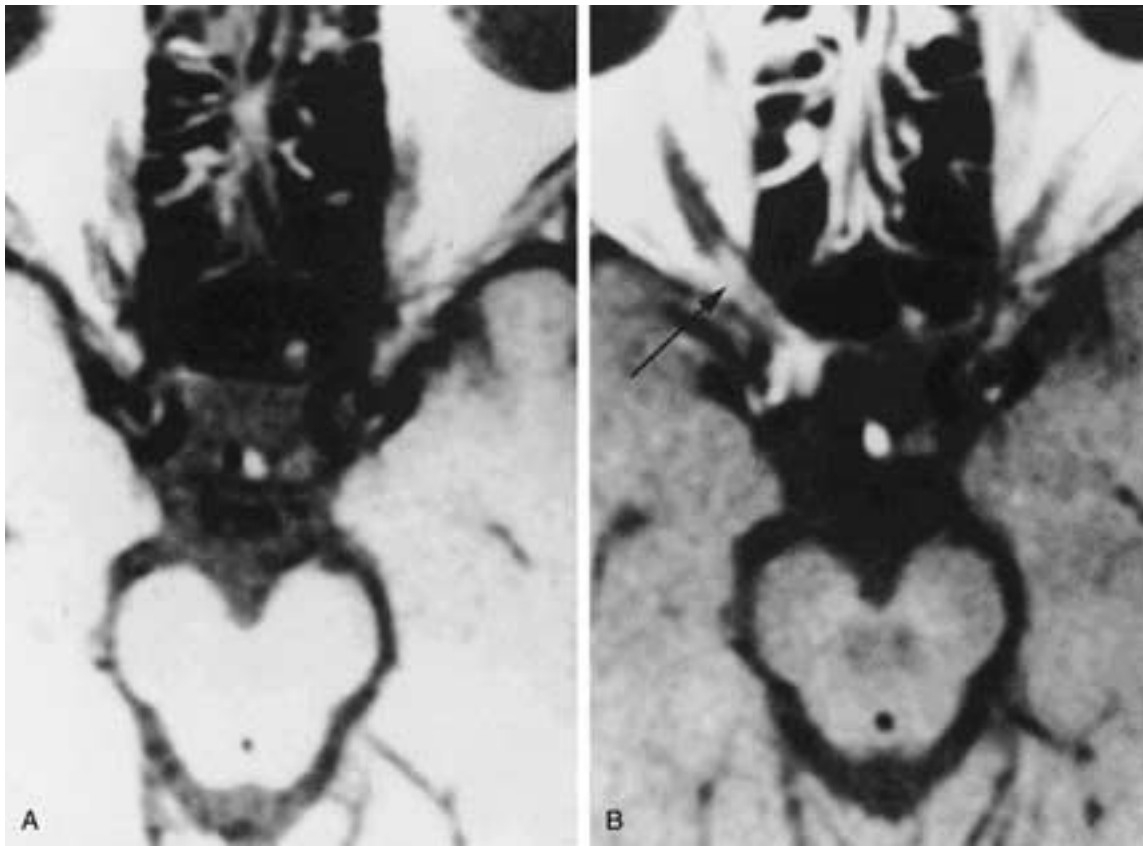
Perioptic meningioma. A, Axial T1-weighted image before administration of gadolinium shows no specific abnormality. B, Axial T1-weighted image after intravenous administration of gadolinium shows enhancement of tumor (*arrow*) that extends from the region of the anterior clinoid process on the right, through the optic canal, and along the optic nerve. Surgery revealed a perioptic meningioma.
